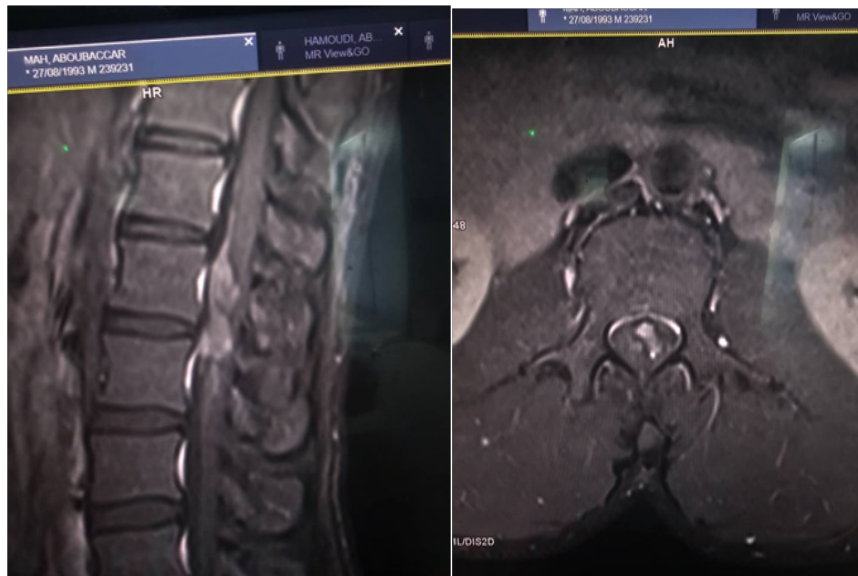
Dorsolumbar MRI in sagittal and axial section, T1 sequence showing lesions compressing the conus medullaris
